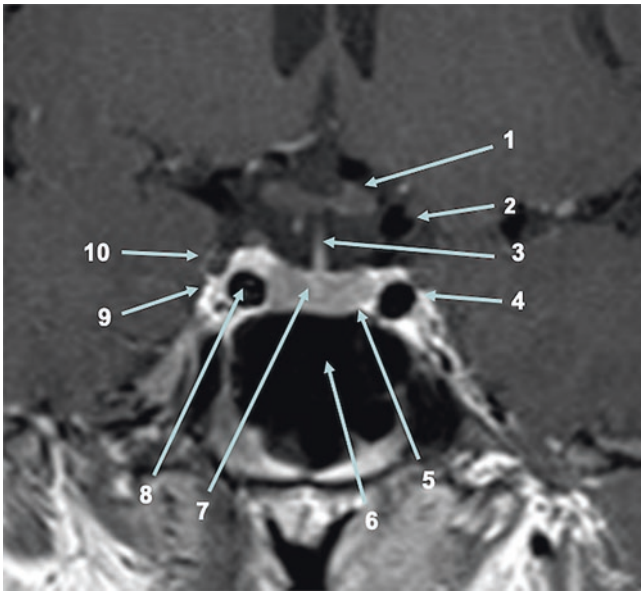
Post-contrast MRI (coronal, T1-weighted image) showing the anatomical structures in the sella and parasellar region. (1) Optic nerve; (2) suprasellar internal carotid artery; (3) pituitary stalk; (4) lateral wall of cavernous sinus; (5) medial wall of cavernous sinus; (6) sphenoid sinus; (7) pituitary gland; (8) intracavernous carotid artery; (9) abducens nerve (nerve VI); and (10) oculomotor nerve (III nerve)
